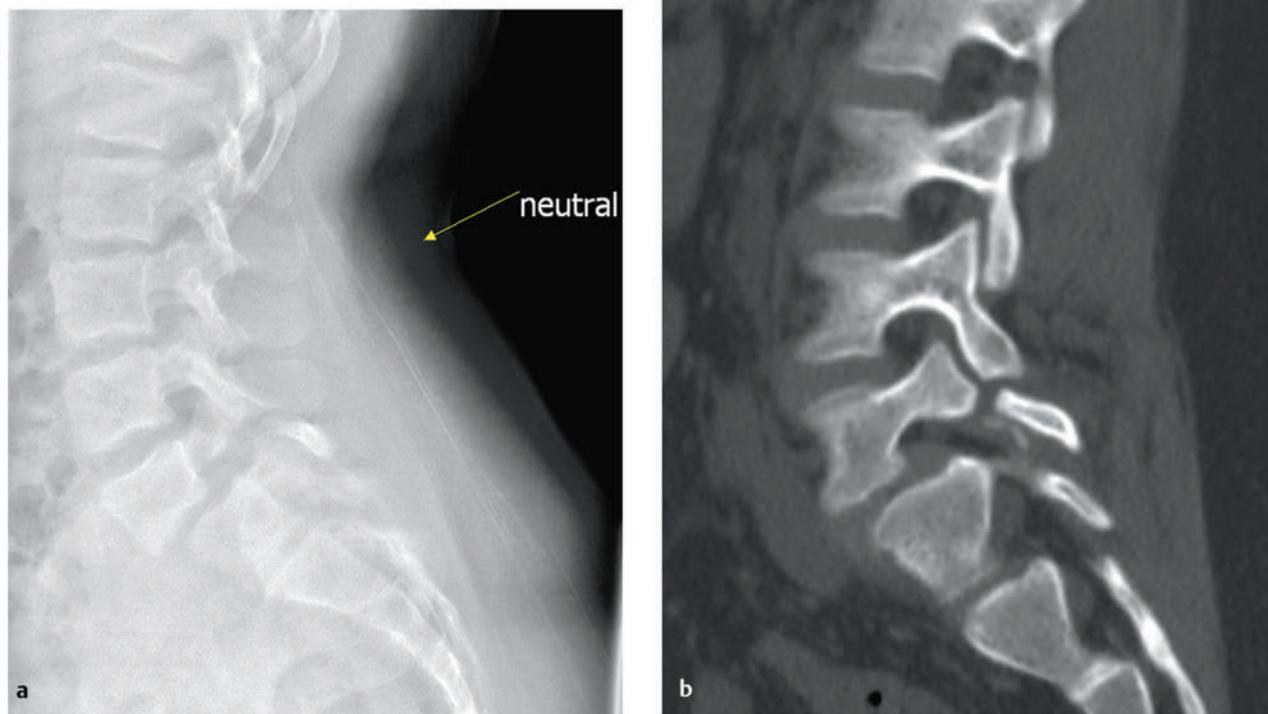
Spondylolysis with spondylolisthesis. (a) Lateral radiograph and (b) sagittal computed tomographic scan demonstrating a chronic post-traumatic L5 pars fracture (spondylolysis) in a young girl with a Meyerding grade 2 anterolisthesis of L5 on S1.
